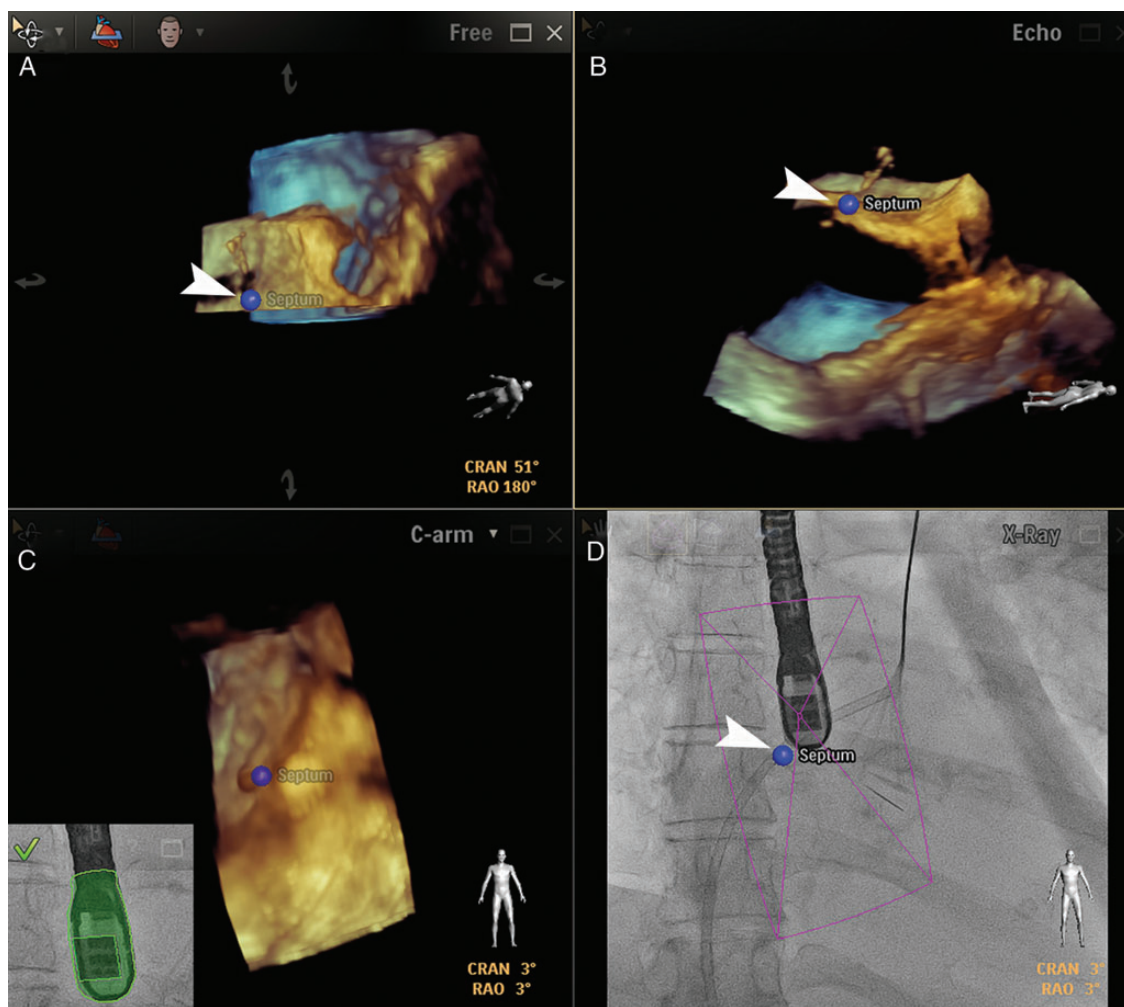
Real-time three-dimensional transoesophageal echocardiography and fluoroscopy fusion: the site of transeptal puncture noted on the three-dimensional images (blue dots, 2A–2C) appears on the fluoroscopy, and marks the site of the puncture (blue dot, 2D).
